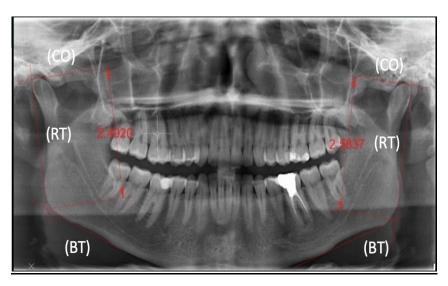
Orthopantomogram interpretation
